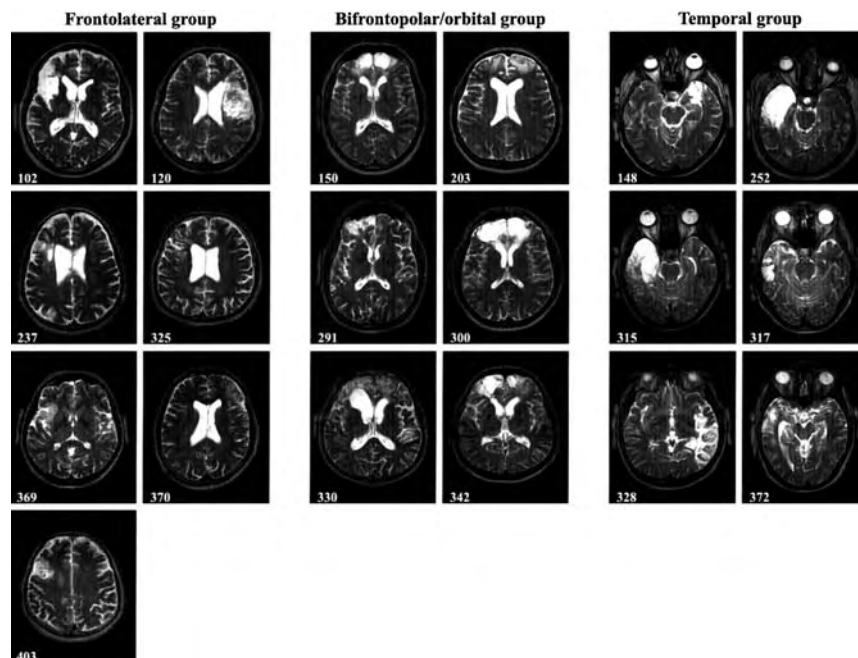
Axial slices of T2 weighted magnetic resonance images of each patient. The left hemisphere is oriented to the left on each image.
